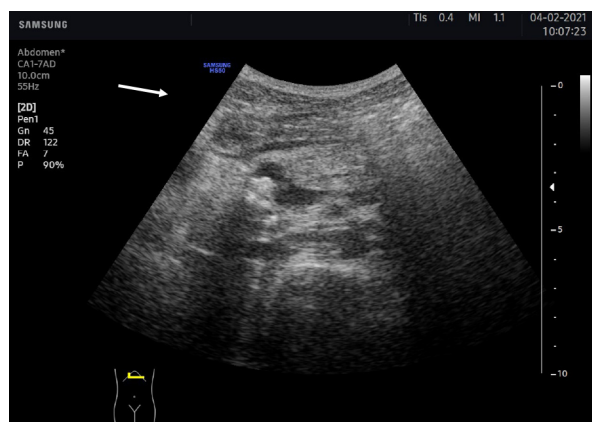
Ultrasound on the day of ESWL – pancreas with dilated duct of Wirsung (star) and a deposit in the head of the pancreas (white arrow)
